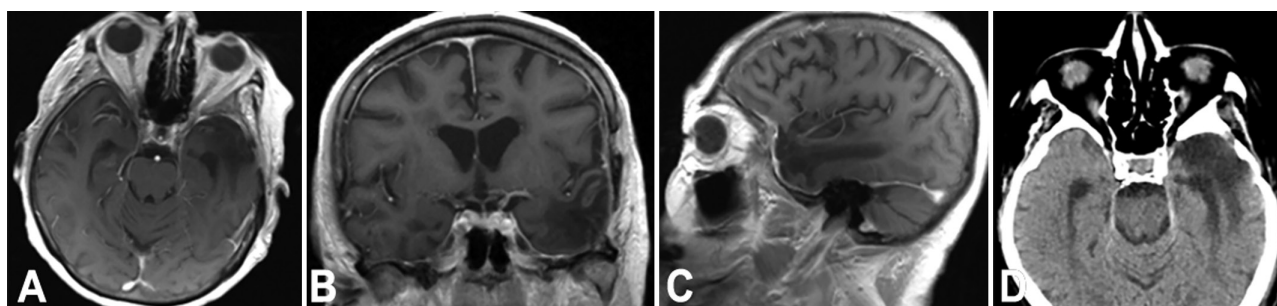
Follow-up neuroimages obtained to evaluate the extent of resection and monitor for disease recurrence. A–C: Axial (A), coronal (B), and sagittal (C) contrast-enhanced T1-weighted MR images demonstrating a stable postoperative surgical bed with no evidence of pathological nodular or linear enhancement—consistent with gross-total resection—and no signs of tumor recurrence. D: Axial noncontrast CT scan confirming the expected postoperative changes, including at the craniotomy site, with no evidence of high-density masses or significant perifocal edema.
